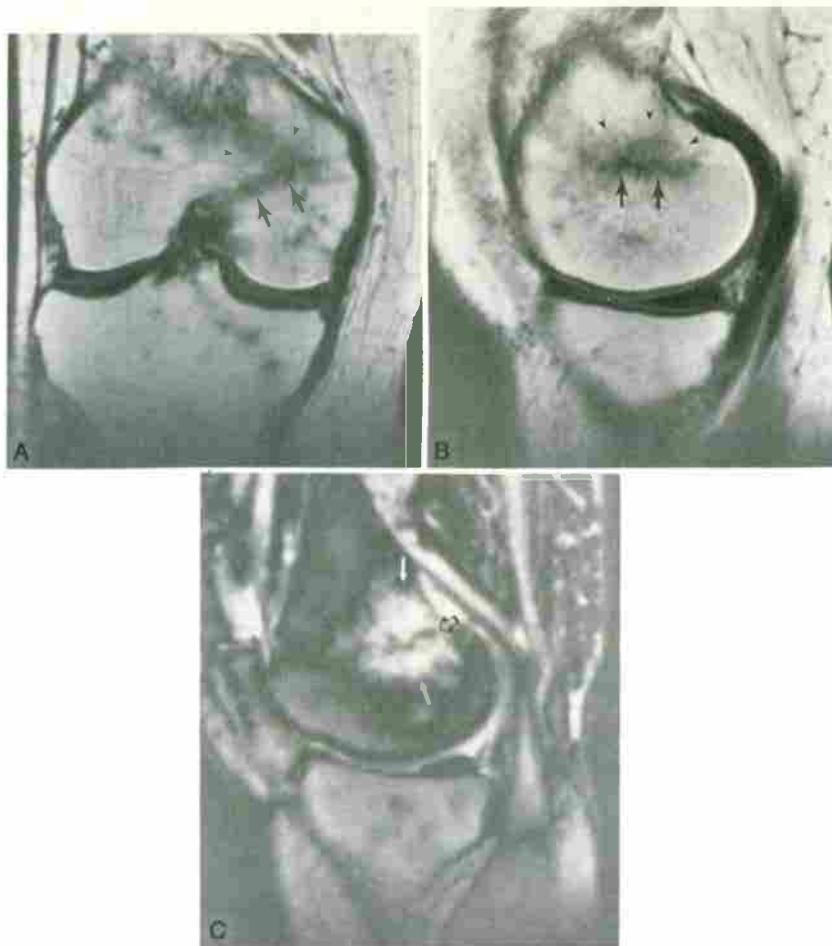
Insufficiency fracture. This elderly woman complained of knee pain approximately 2 months after undergoing a left total hip replacement. A, Coronal and (B) sagittal T1-weighted (TR/TE, 430/20) images demonstrate a low-signal linear insufficiency fracture (arrows) of the medial femoral condyle. Surrounding edema (arrowheads) appears as a more diffuse, ill-defined low-signal-intensity pattern. C, Sagittal STIR (TR/TE, TIR1, 3600/19, 150) image again shows the linear insufficiency fracture (open arrow). Note the increased conspicuity of surrounding marrow edema on STIR images, which appears as diffuse confluent high signal intensity (white arrow).
